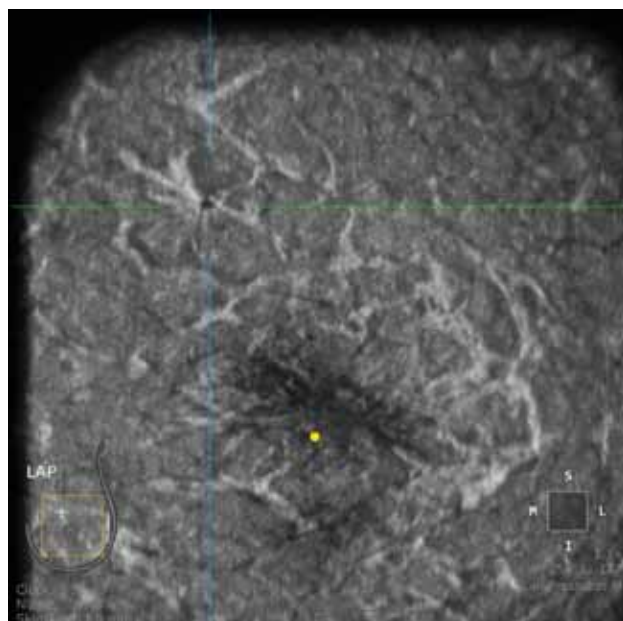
A 6mm invasive ductal carcinoma seen on automated breast ultrasound in a 72-year-old asymptomatic female. The lesion was not seen on screening mammogram due to increased breast density.
